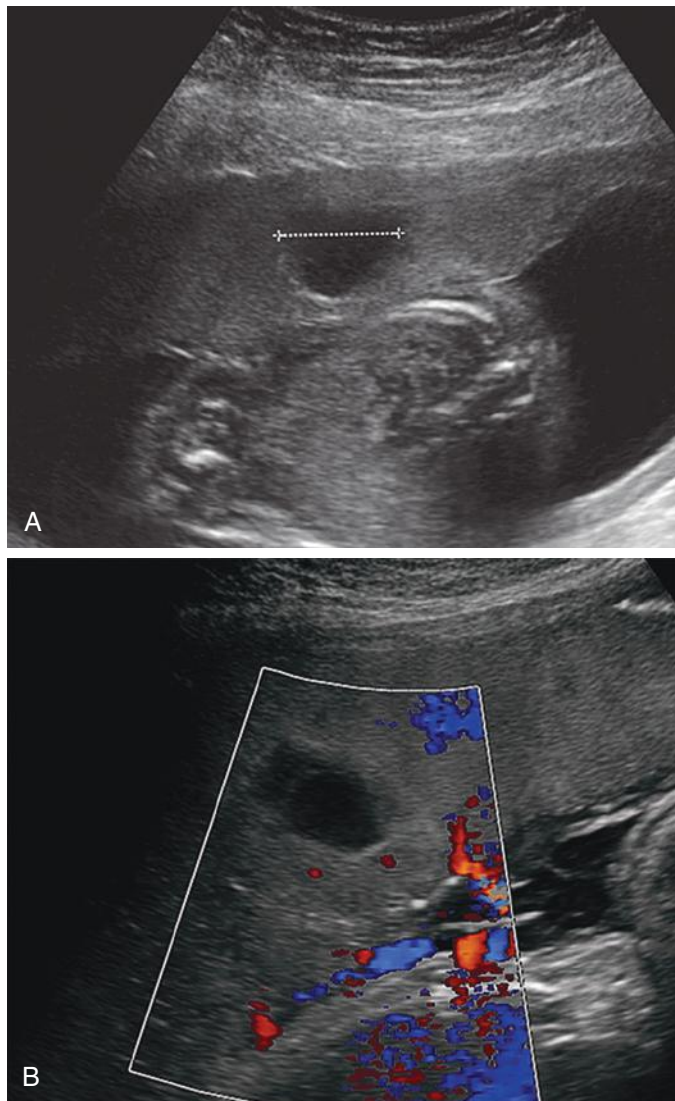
Placental sonolucencies. A, A sonolucency measuring 2 cm in diameter is visible within an otherwise homogeneous placenta at 20 weeks' gestation. B, Color Doppler sonographic imaging at 34 weeks' gestation demonstrates absence of flow within the hypoechoic cystic space.
